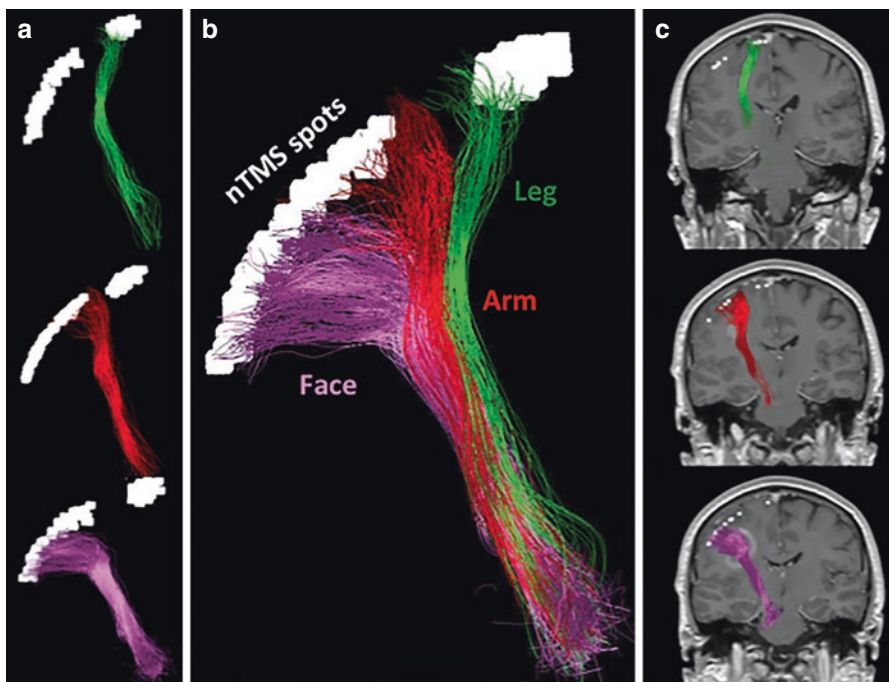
3D reconstruction of an nTMS-based somatotopic DTI FT of the CST. (a) 3D reconstruction of each functionally different fiber bundle (leg = *green*, arm = *red*, face = *purple*) forming the CST with the corresponding nTMS map (*white spots*); (b) coronal view of the whole somatotopic 3D reconstruction of the CST; (c) navigable tractography after coregistration with a reference anatomic MRI examination
